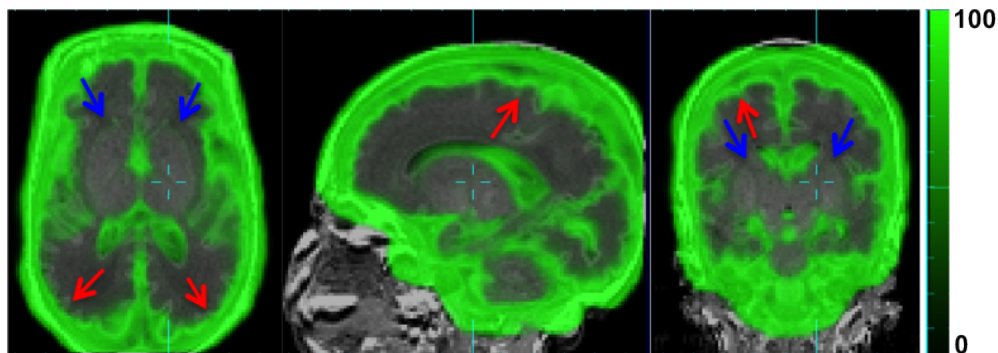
Age-specific Patch Contribution (PC) map (green) overlaid over raw MR image (grayscale). PC values are on a scale of 0 - 100. Red arrows: high PC values in cortical regions at sCSF/GM and GM/WM boundaries. Blue arrow: low PC values at WM/DGM boundary and inside WM, DGM.
